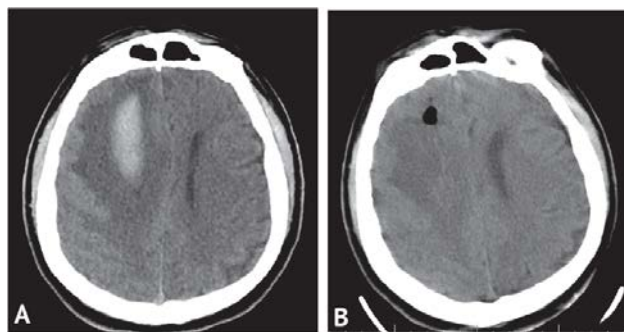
CT scan of the brain, axial projection: A — before surgery; subacute subcortical hematoma of the right frontal lobe with a volume of 33 ml, transverse dislocation to the left up to 6 mm; B — 1 hour after endoscopic aspiration of the ICH; the hematoma is removed completely, the transverse dislocation to the left up to 2 mm, a small amount of gas in the bed of the removed hematoma
